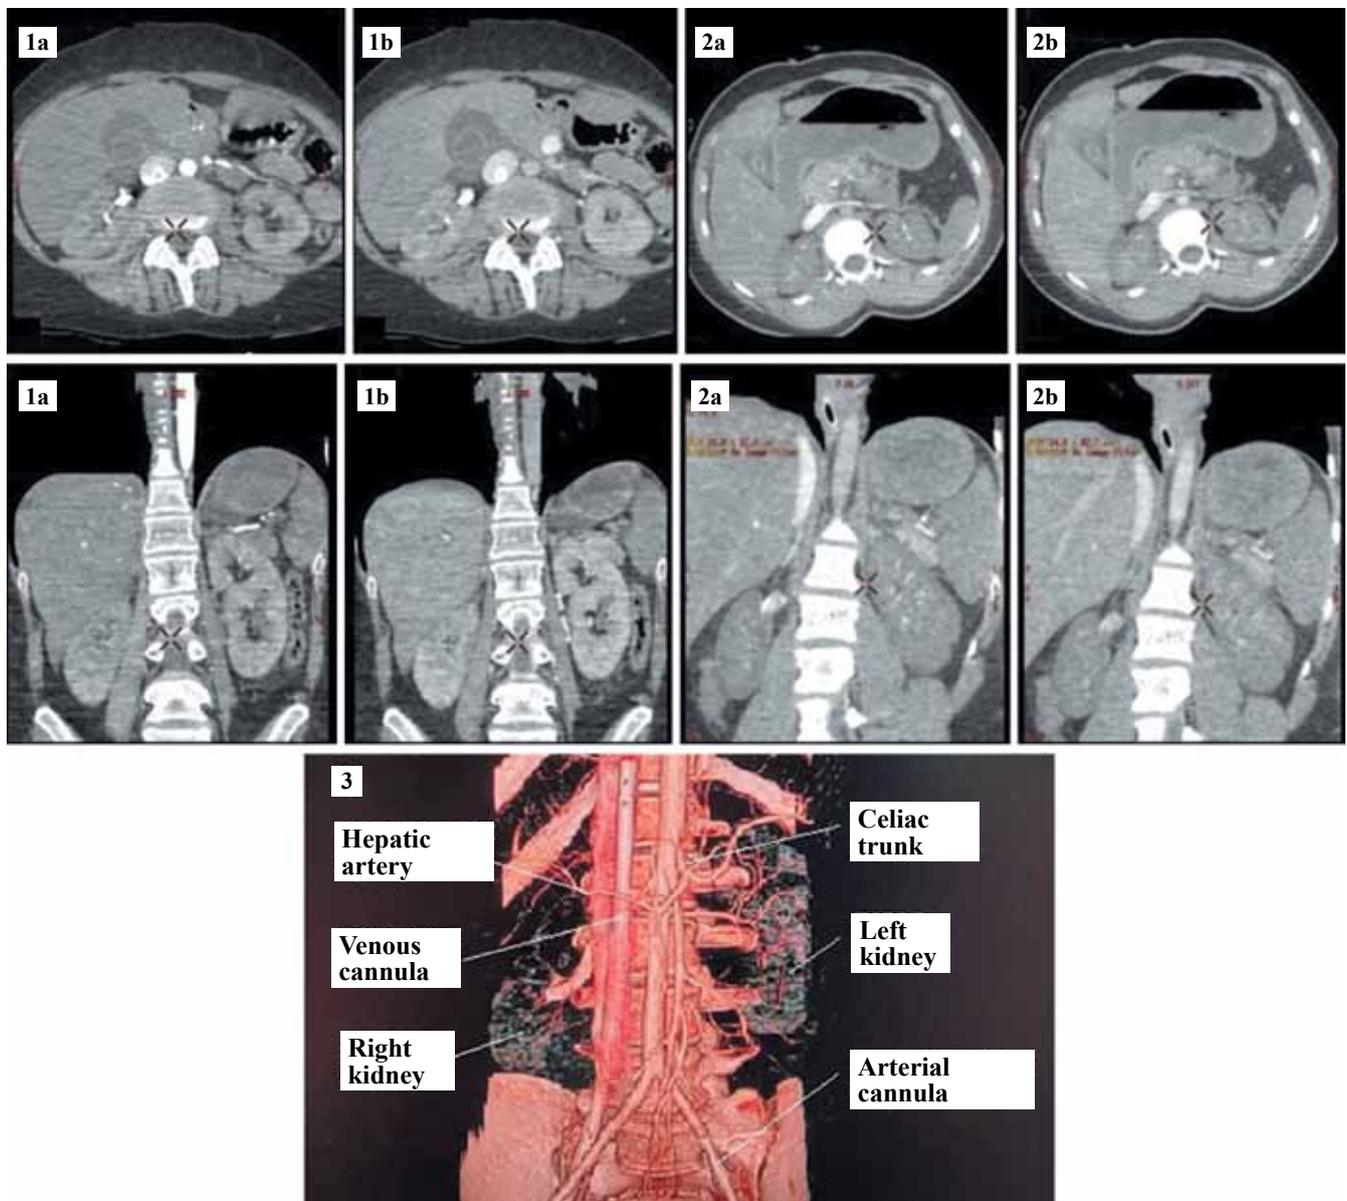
Results of intravenous contrast-enhanced CT in a potential donor during ECMO (1 – satisfactory perfusion of the liver, kidneys (1a – arterial phase, 1b – venous phase); 2 – no perfusion (1a – arterial phase, 1b – venous phase); 3 – 3D reconstruction, arterial phase, satisfactory perfusion of abdominal region)
